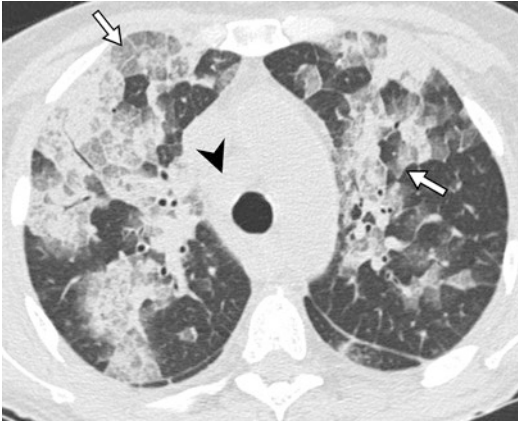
Diffuse alveolar hemorrhage in a 56-year-old man with non-Hodgkin lymphoma. CT scan demonstrates diffusely demarcated ground-glass opacities with some interstitial septal thickening (crazy-paving pattern) (arrows). Note paratracheal lymphadenopathy (arrowhead)
